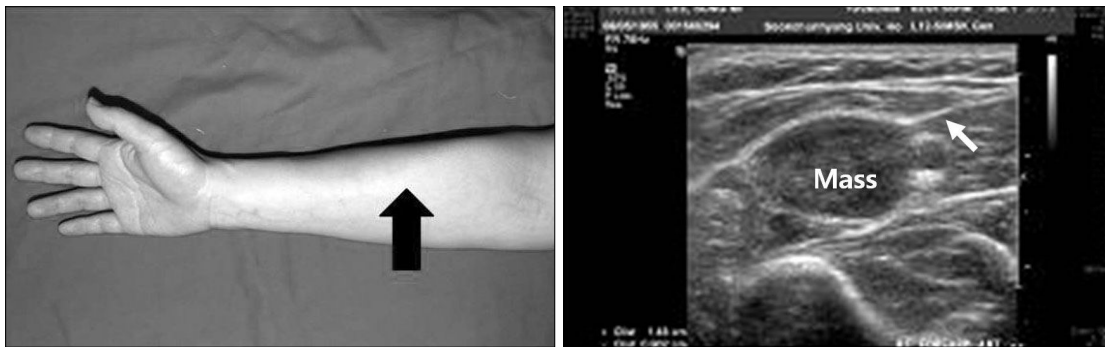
(Left) A 55-year-old woman was presented with 2 \times 1 cm mass on the right midforearm (arrow). (Right) Sonography of schwannoma. Longitudinal sonogram of a mass reveals an ovoid, well-defined mass with a heterogenous and hypoechoic pattern. The mass was eccentrically located in the superficial radial nerve (arrow).
